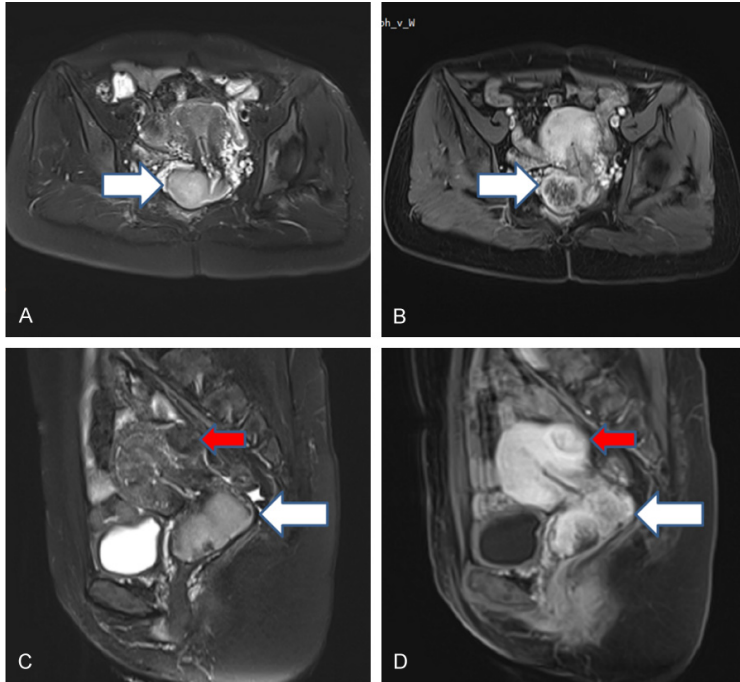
MR image of a 46-year-old patient with cervical squamous cell carcinoma. A. T2 fat suppression sequence (axial position) shows a high signal mass (white arrow) on the right side of the posterior lip of the cervix. B. T1WI enhanced sequence (axial view) shows that the cervical mass is obviously unevenly enhanced, with the main edge enhancement. C. T2 fat suppression sequence (sagittal position) shows a high signal mass on the posterior lip of the cervix, uneven signal in the lower posterior part (white arrow), and a smaller and slightly lower confounding signal nodule on the posterior wall of the uterus. The posterior pathology showed uterine fibroids (red arrow). D. T1WI enhancement sequence (sagittal view) showed obvious uneven enhancement of cervical mass (white arrow), and uneven and obvious enhancement of posterior wall fibroids (red arrow).
